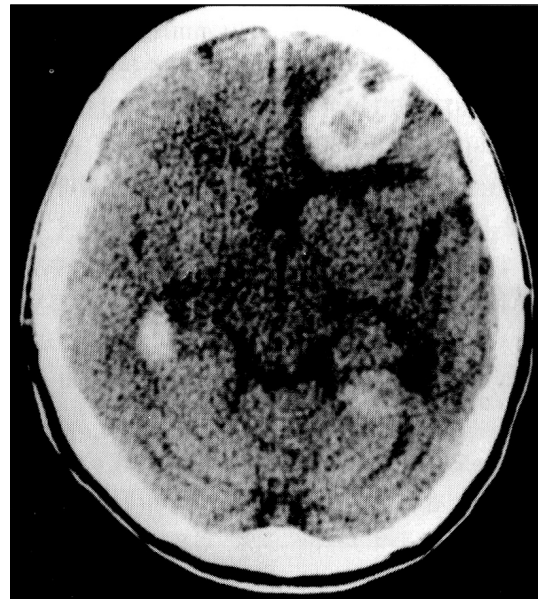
Brain CT taken on the 15th hospital day shows multiple hemorrhagic infarctions of brain.
